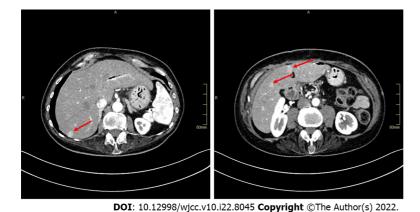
Abdominal computed tomography images revealing several hypervascular liver metastases (arrows).
